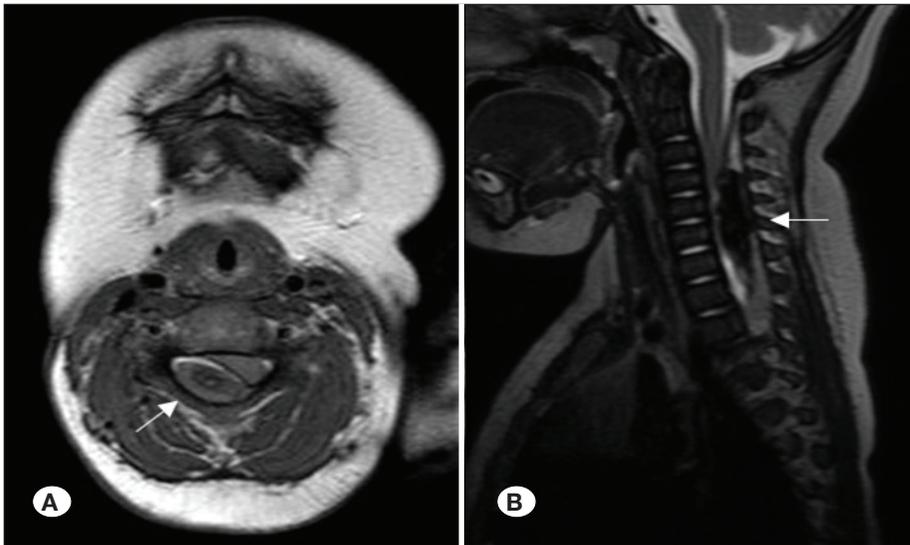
Cervical magnetic resonance imaging shows an acute hematoma compressed against the spinal cord over the right anterolateral aspect at the C3-T1 level (A: axial, B: sagittal).
